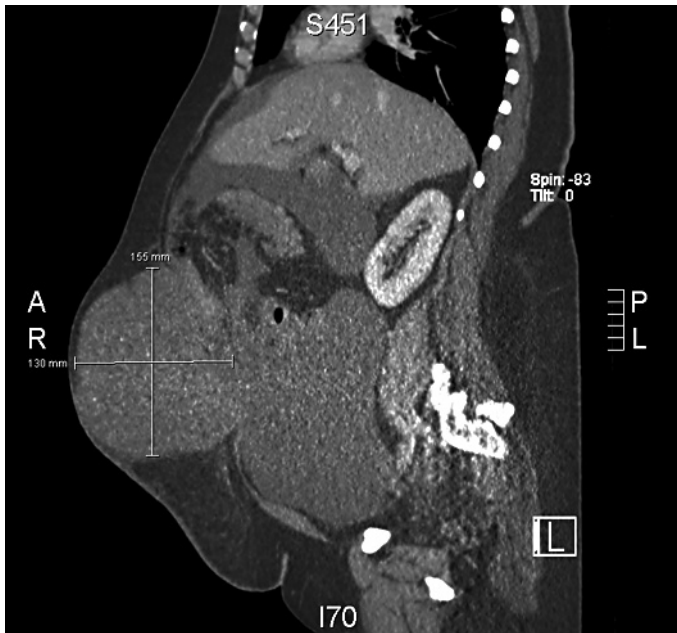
CT scan: Sagittal view shows a lot of ascites presenting in the lower abdomen and in the huge umbilical herniation.
